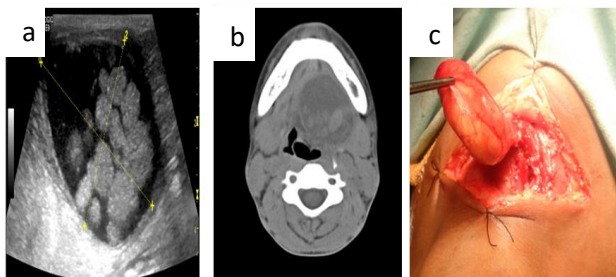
(a) Globular complex cystic lesion with multiple discrete echogenic nodules. (b) CT scan showing midline neck swelling. (c) Intra-operative image of Midline epidermal inclusion cyst showing adhesion with neighbouring muscles.
